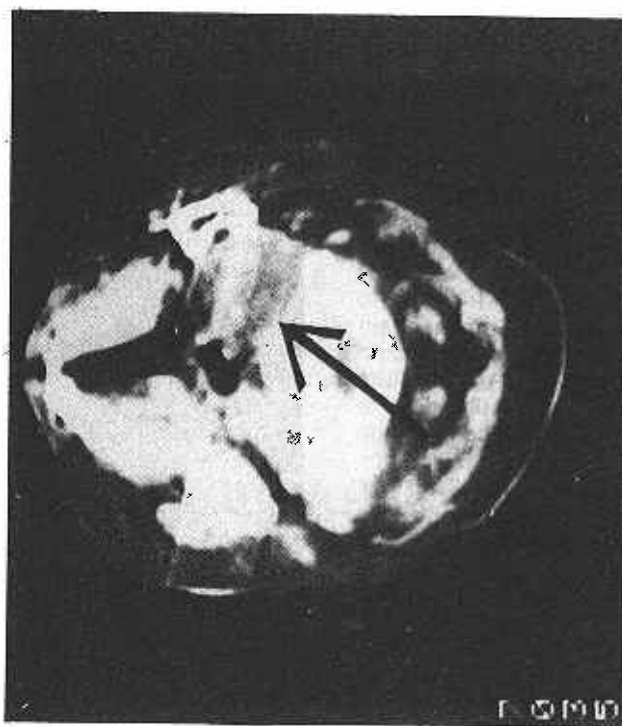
CT scan showing a mass (arrowed) in the nasopharynx
